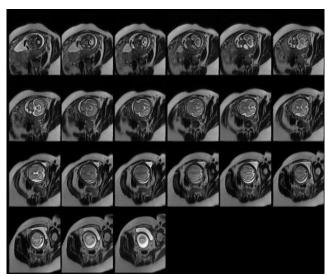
A volume of Fetal MRI of normal brain (GW 20)
